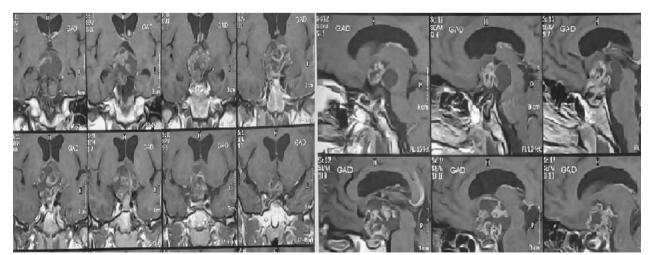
Preoperative MRI of patient 2
